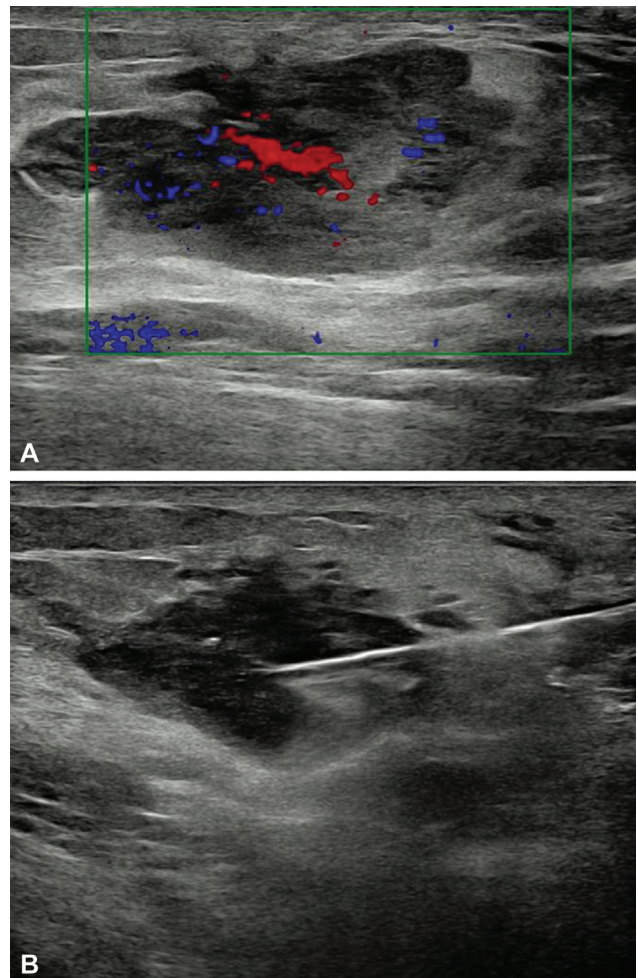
Ultrasonography demonstrates an irregular shape, parallel orientation, microlobulated margins, heterogeneously hypoechoic mass with posterior enhancement in left breast at 8 to 9 o'clock position in zone two with an area of increased vascularity (A). A biopsy needle is seen within the lesion (B).
